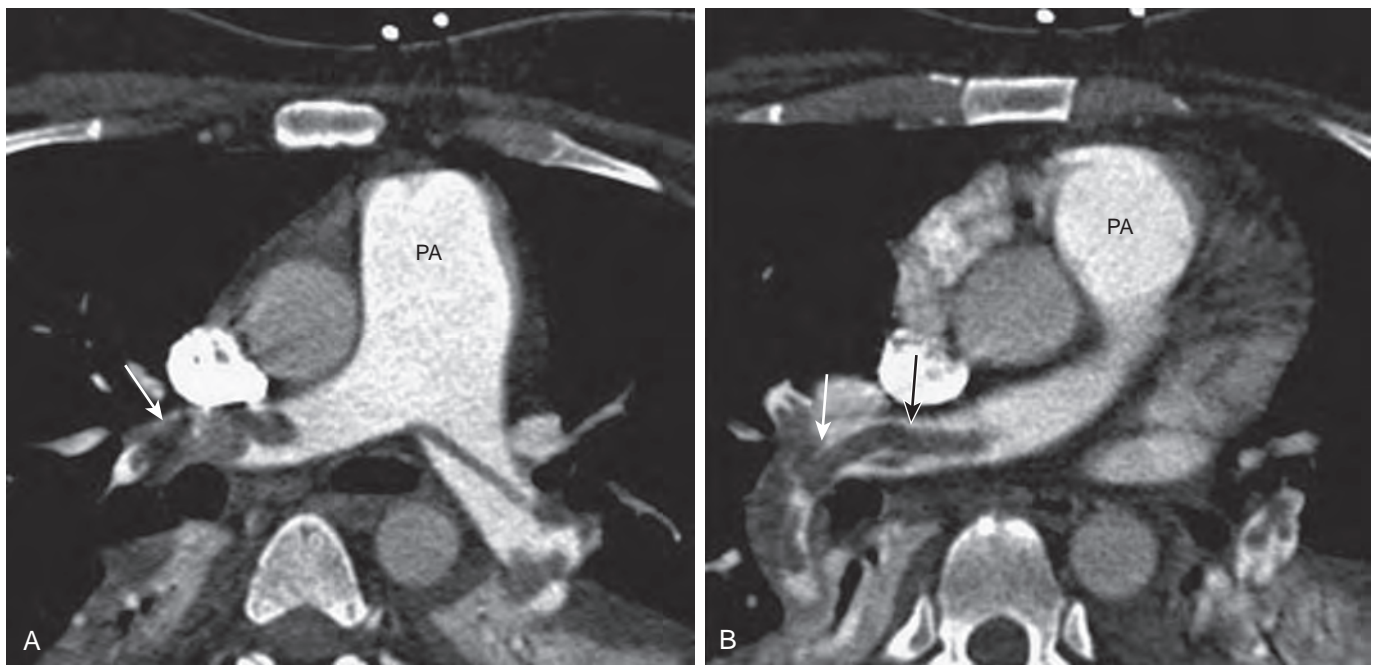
A and B, Computed tomography angiography shows large pulmonary emboli (arrows) at two different axial scan levels. PA, Pulmonary artery.
